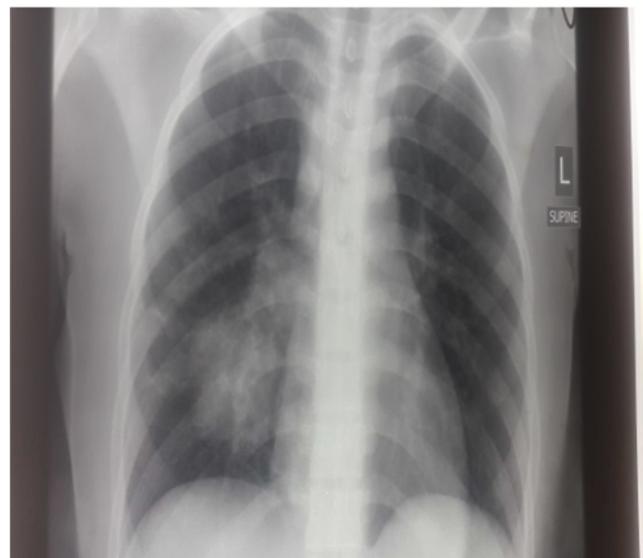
Chest Xray showing a heterogeneous opacification of lower lobe of right lung.
